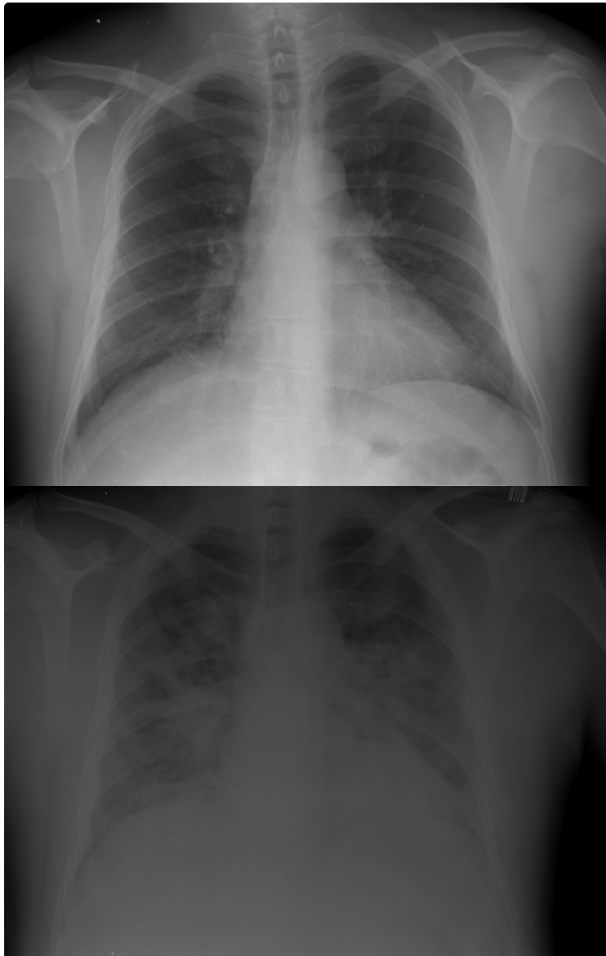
Patient aged 31 years with high fever, cough and scanty expectoration of 4 days evolution. Admission chest radiograph (top) and at 48 hours (below) prior to intubation. Diagnosis: viral pneumonia by A/H1N1v.
